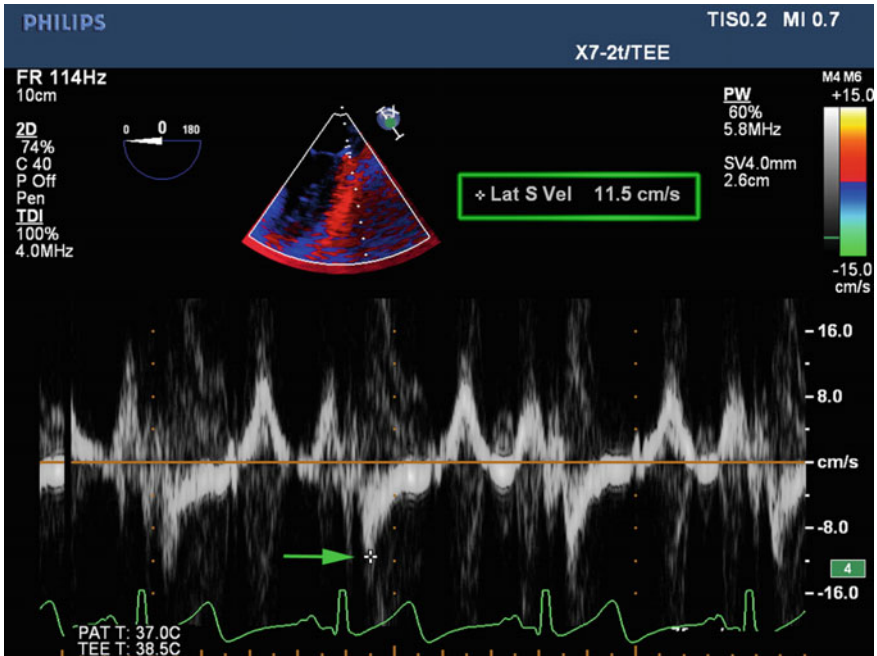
Tissue Doppler-based calculation of the lateral mitral annular velocity during systole (*green arrow*). The measurement is obtained below the baseline since during systole the annulus movement is downward toward the apex
